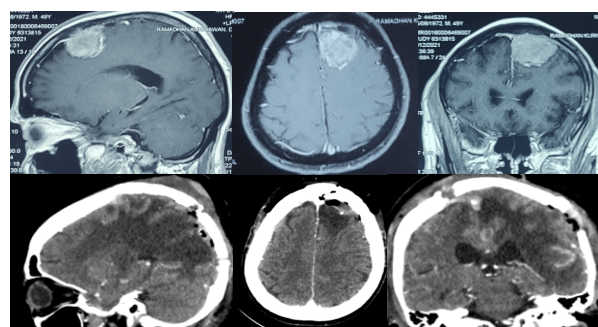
Comparison of pre-operative (MRI) and post-operative (non-contrast CT) imaging in sagittal, axial, and coronal views for case 4.
